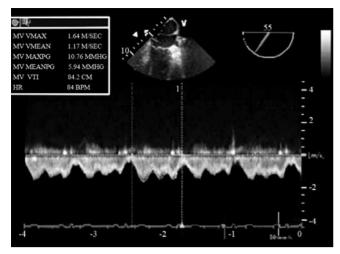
Doppler flow imaging across the membrane orifice (transesophageal echocardiography (view)
